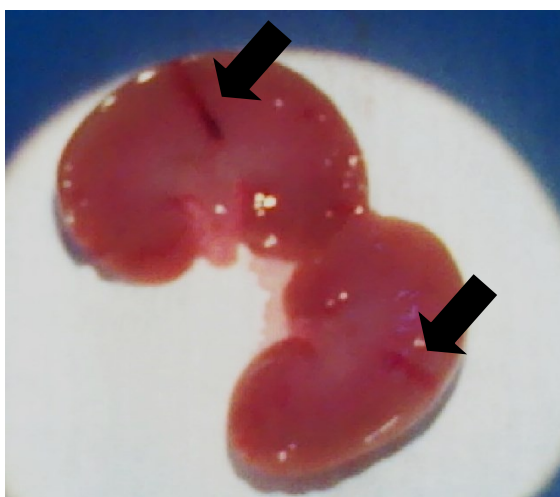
Post mortem* examination of the left kidney confirmed correct placement of the needle laser Doppler probe into the renal medulla (arrows).
